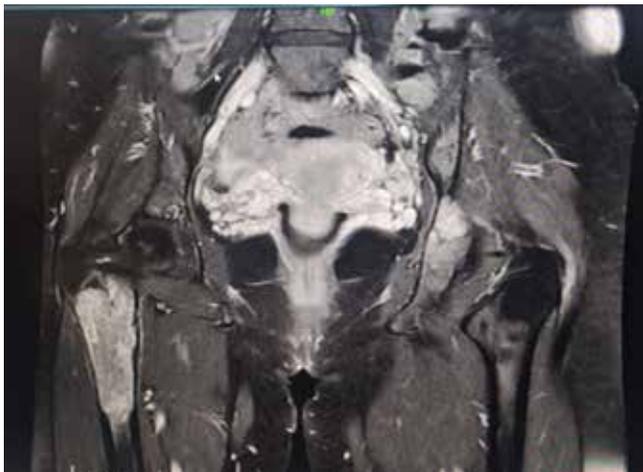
MRI right proximal femur suggestive of characteristic high-flow vascular channels consistent
